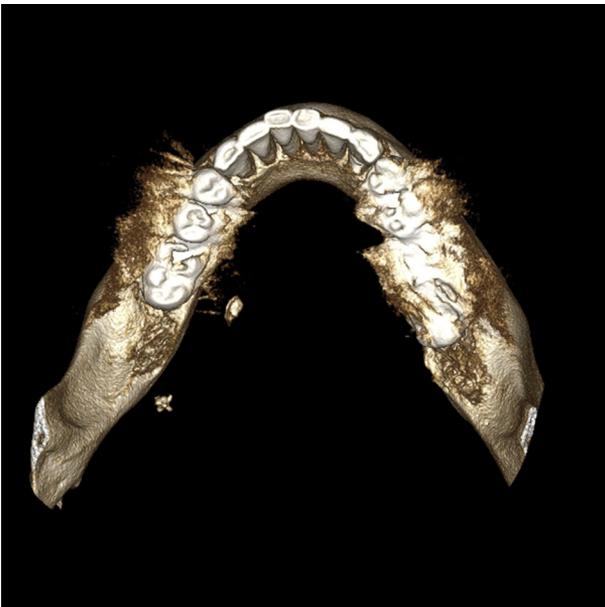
Patient 3. Cone-beam computed tomography image, 3-dimensional superior view.
